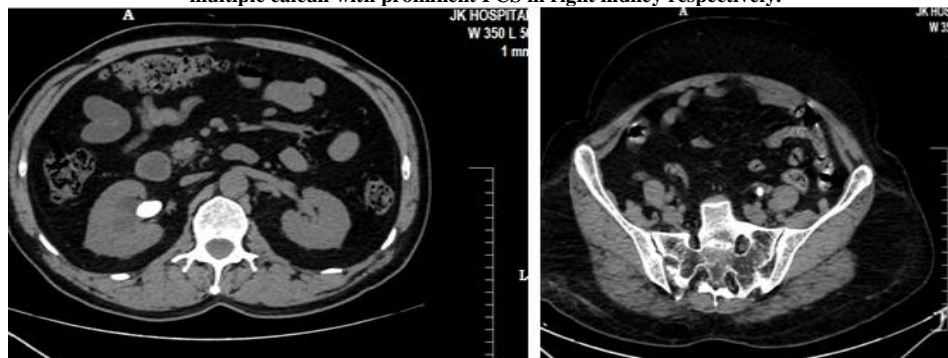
Axial CT images of 47 year male & 55 year old female showing hyperdense calculus (Avg-HU 1332)at right PUV causing mild hydronephrosis & hyperdense (Avg-HU 940) calculus at left mid ureter respectively.
